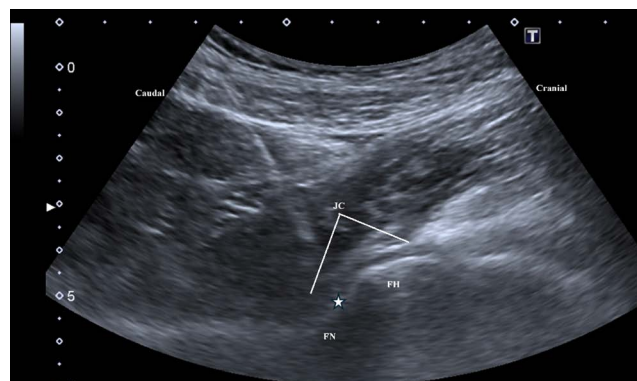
Ultrasound-guided intra-articular hip injection. The asterisk indicates the needle tip positioned within the joint capsule.
